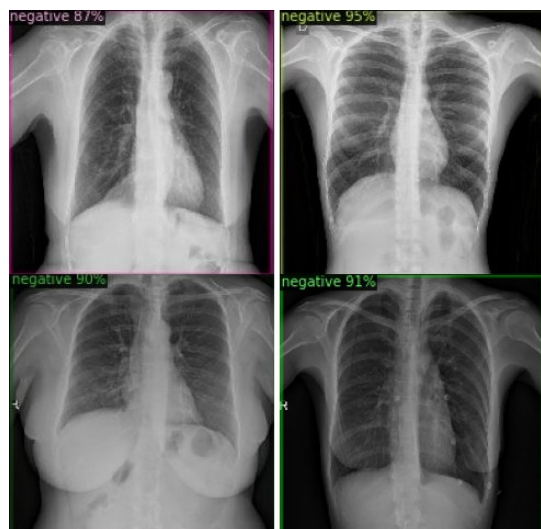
Chest X-ray images of negative cases.
